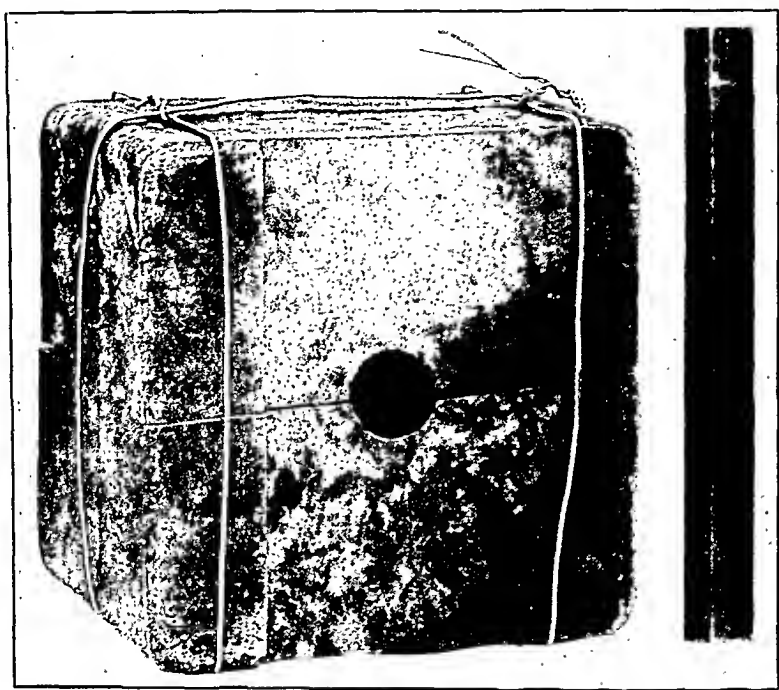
Block of cast iron with a large hole leading off one face. Assembled after cutting and radiographed in Figure 27.
